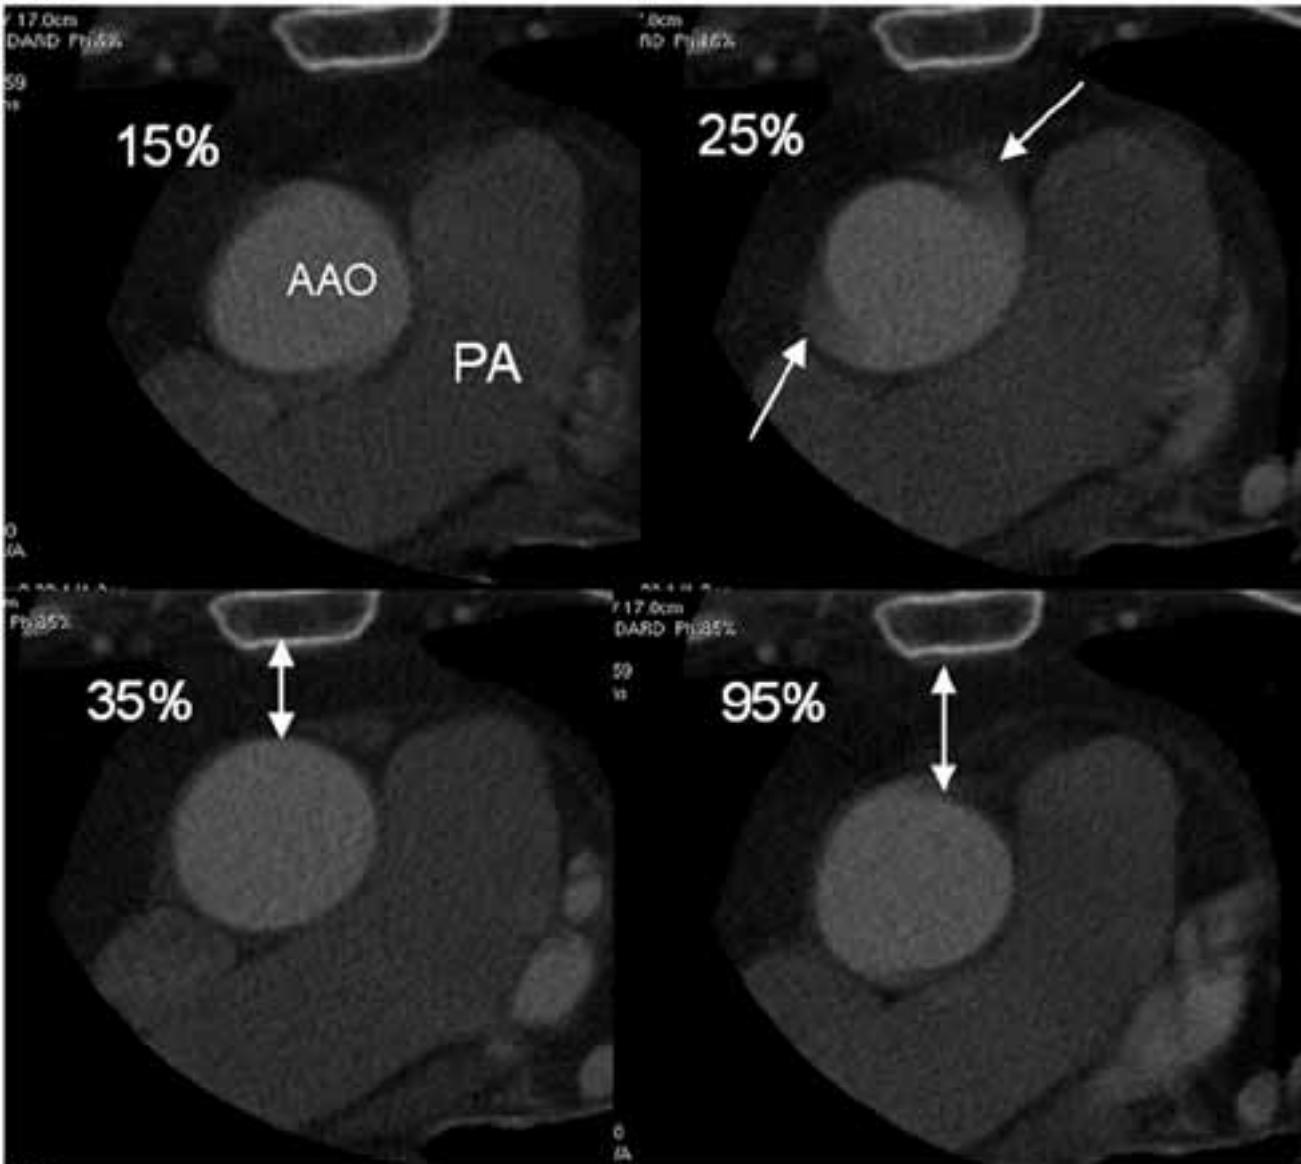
Changes in the aortic location, shape, and size within the RR interval. Four panel images of a multidetector computed tomography scan display the reconstructed images of the 15%, 25%, 35%, and 95% phase of the RR interval. The 35% phase is end-systolic and 95% phase is end-diastolic. The 25% phase has the most motion artifact (white arrows) and 35% phase has the most anterior location, cyclical shape, and the fewest motion artifacts. The distance between the aorta and sternal bone was 3.5 and 6.5 mm; the diameter was 31 and 29 mm in 35% and 95%, respectively (white dual arrow).
